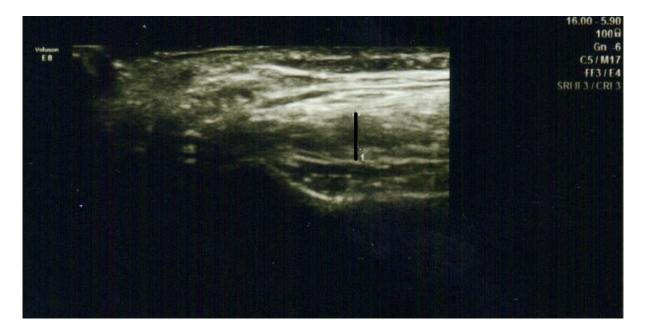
Ultrasonography of lateral pterygoid muscle
